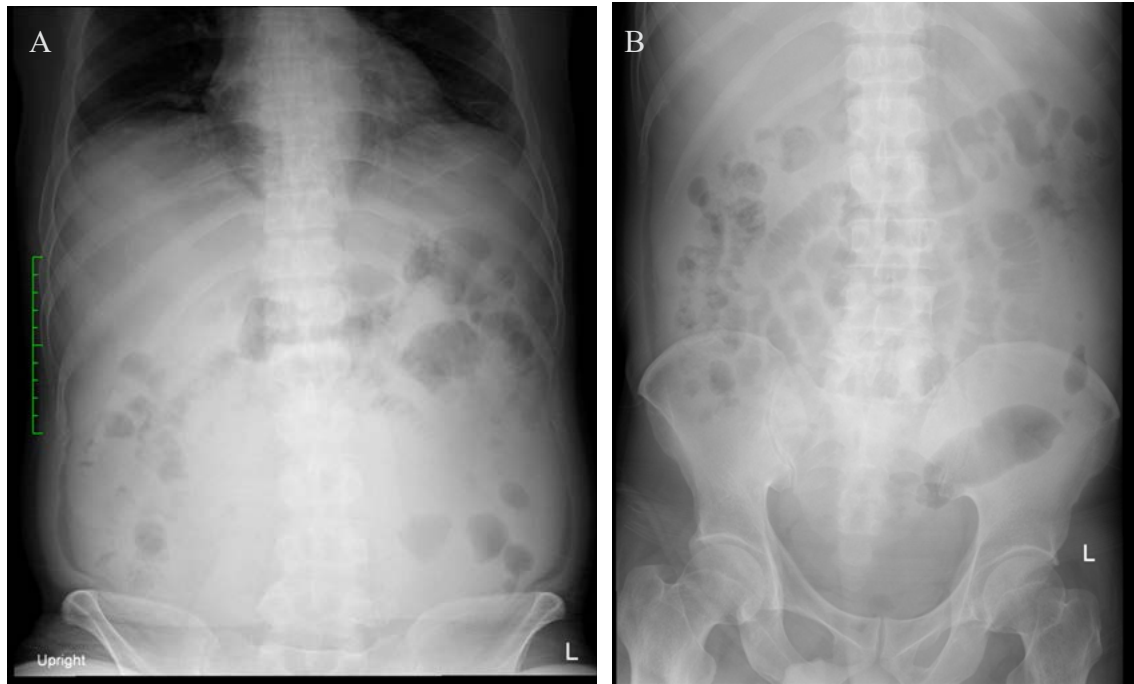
A two-view abdominal Blass Nier Overzicht (BNO) X-ray (A and B) revealed a localized mid-abdominal ileus, with prominent gas distention visible in several small bowel loops.
